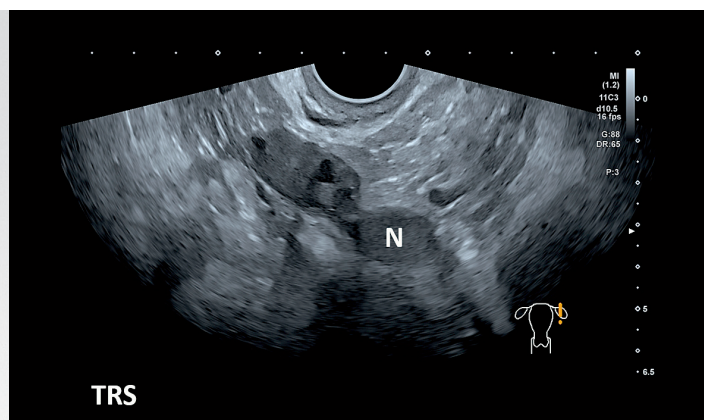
Images confirming the need for a flexible scanning approach to ultrasound investigation of endometriosis. Transrectal scanning (TRS) clearly demonstrates endometriotic nodules (N) in [a] and [b].
